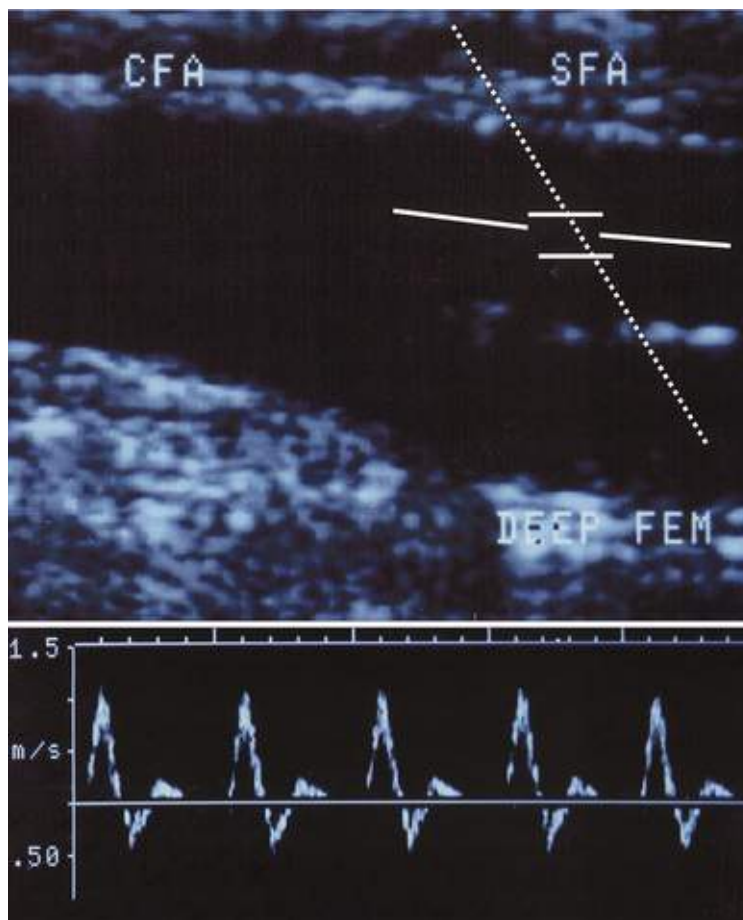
Duplex ultrasonogram of the common femoral artery (CFA) bifurcation into the superficial femoral artery (SFA) and deep femoral artery. The upper image shows a normal gray-scale image of the artery in which the intima is not thickened and the lumen is widely patent. The lower image is a recording of the pulse Doppler velocity sampled from the superficial femoral artery. The triphasic profile is apparent, the envelope is thin, and peak systolic velocity is within normal limits.
